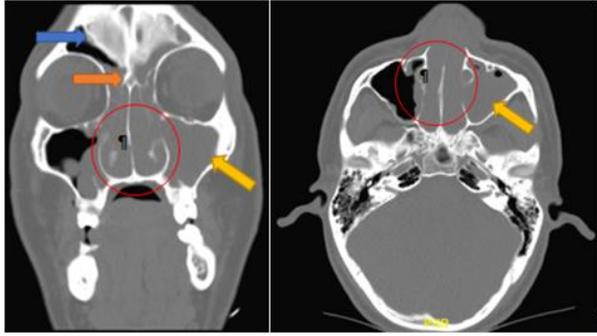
CT-Scan examination revealed a sinonasal tumor.
